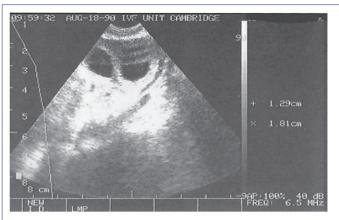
Transvaginal ultrasound scan of a human ovary showing two developing follicles, the largest of which has an average diameter of about 1.6mm. (Source: Professor Peter Braude.)
